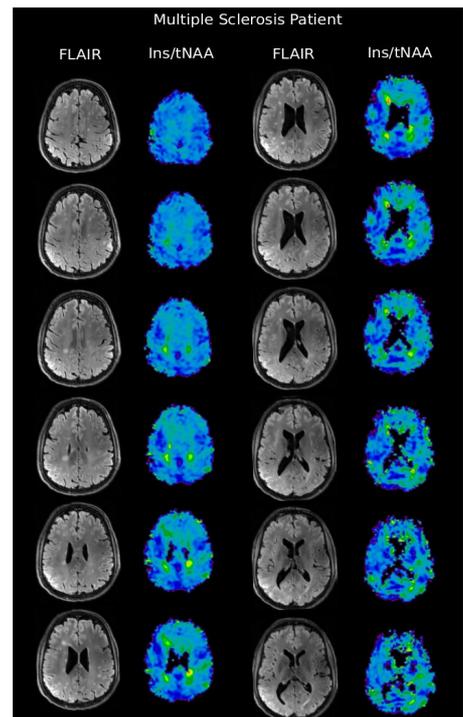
Ins/tNAA ratio maps for the MS patient together with FLAIR images.
